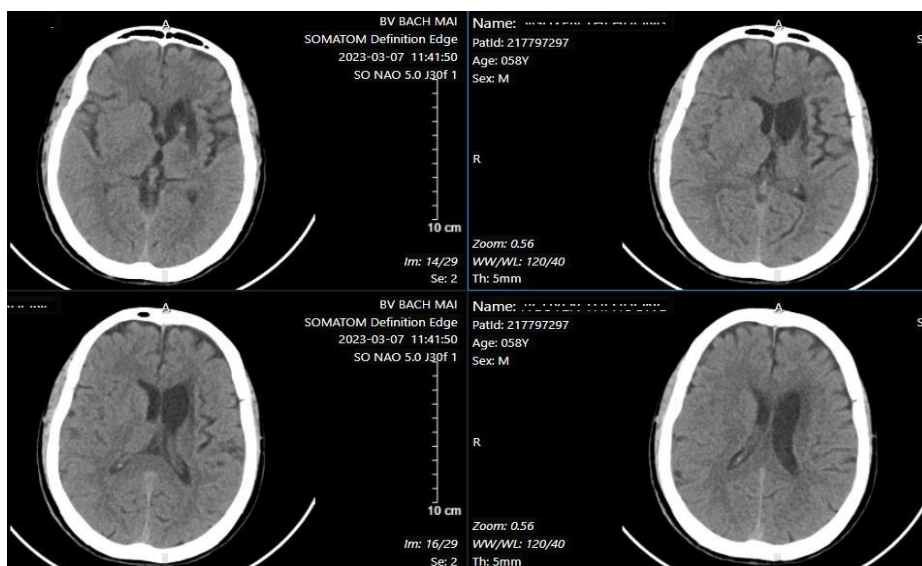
Image of brain parenchyma on CT film 24 hours after fibrinolysis
